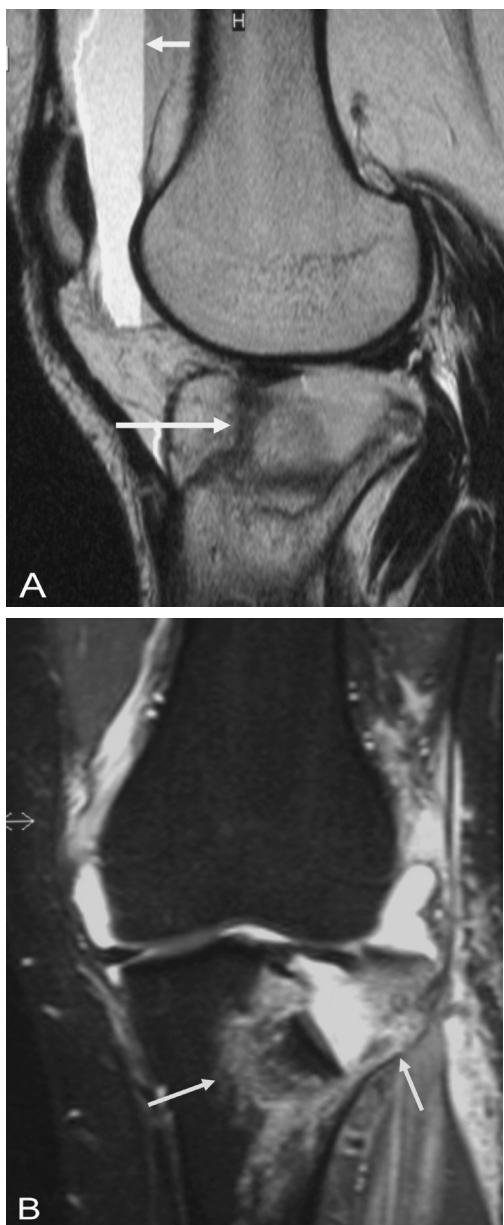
Fracture. (A) Sagittal T2-weighted turbo spin-echo image. Intra-articular fracture of the tibial plateau (long arrow) with an associated lipohemarthrosis in the suprapatellar recess (short arrow). (B) Coronal short tau inversion recovery image shows extensive bone marrow edema surrounding the fracture (arrows).
